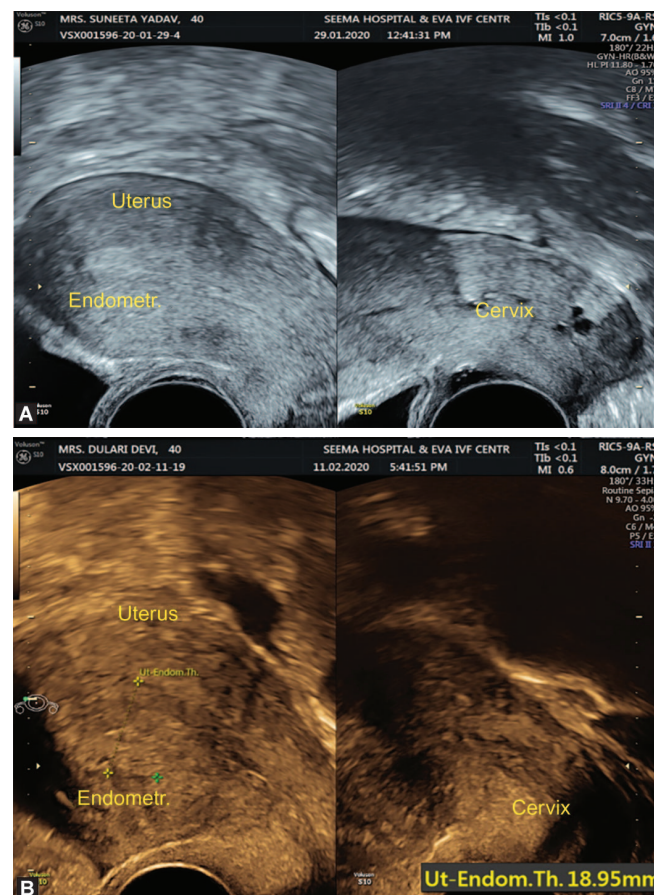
Ultrasound image showing normal triple line endometrium and endometrial hyperplasia
